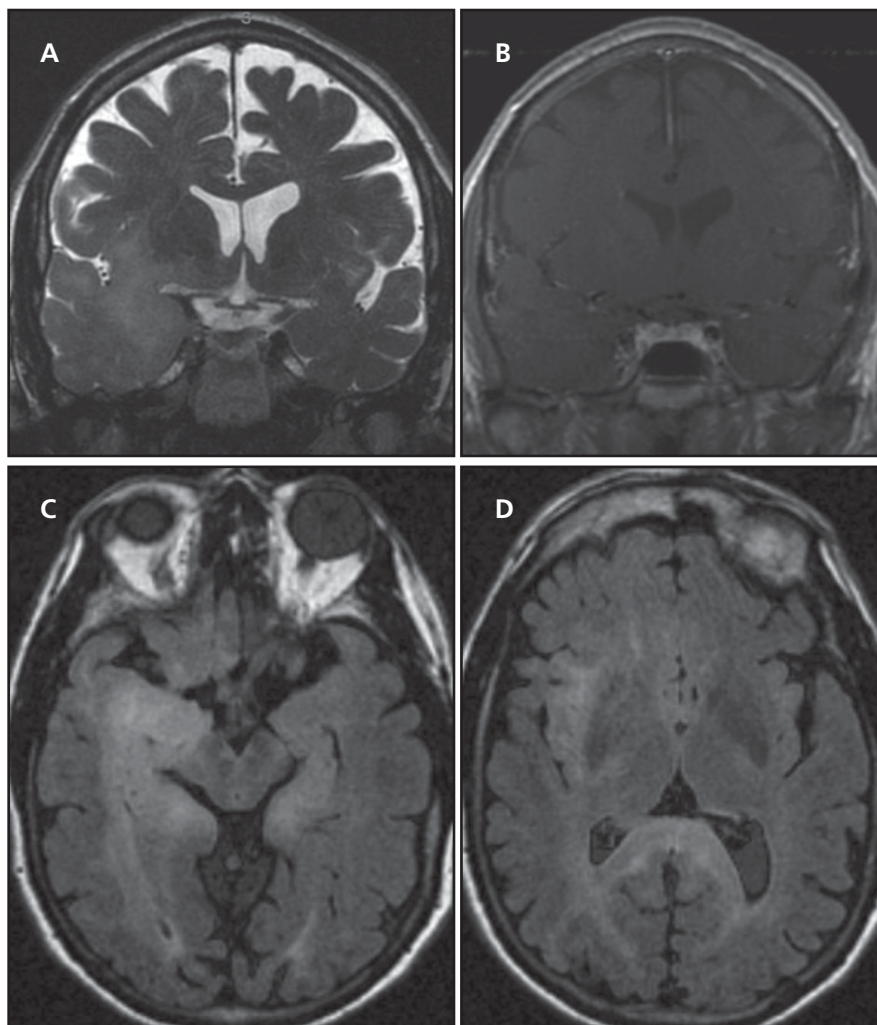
Gliomatosis cerebri. Coronal fast multiplanar inversion recovery (FMPiR) image (A) demonstrates abnormal hyperintense signal and mild swelling involving the right insula, temporal lobe, and inferomedial frontal lobe without enhancement on postcontrast T1 (B). Axial FLAIR images (C and D) show further extent of signal abnormality to also involve the splenium and contralateral mesial temporal lobe.
